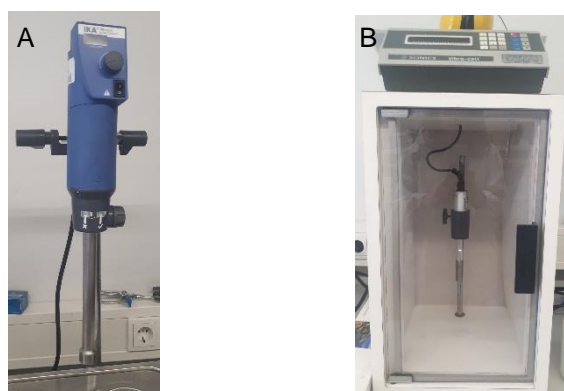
Equipment; A - Mechanical homogenizer T25 Digital UltraTurrax®; B - Ultrasonic probe Vibra Cell VCX130.
